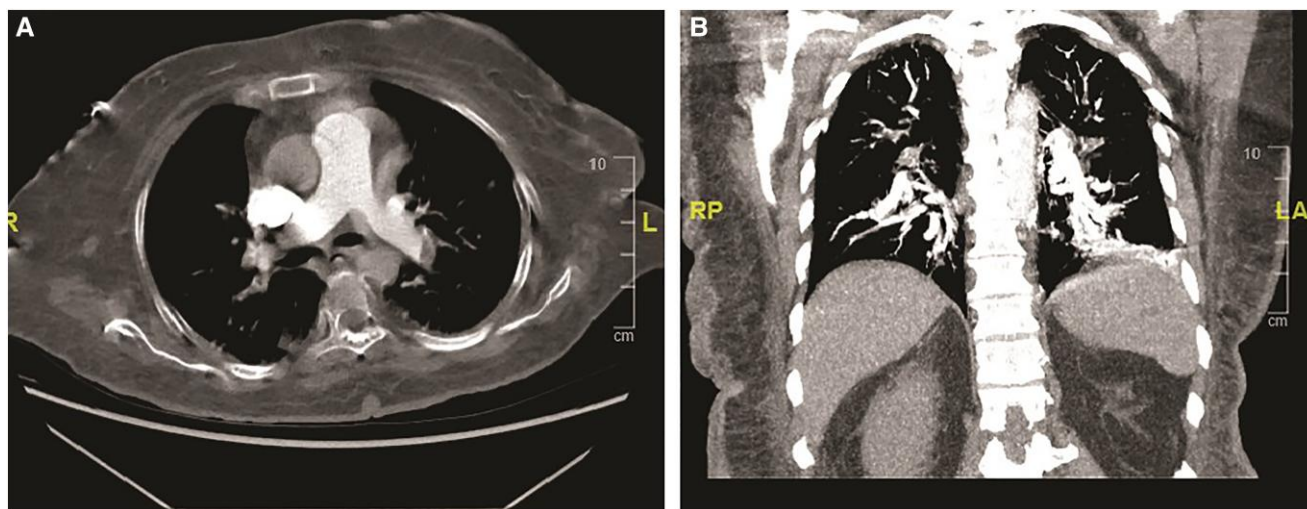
(A & B) Computed tomography pulmonary angiogram shows segmental and subsegmental pulmonary embolism.
